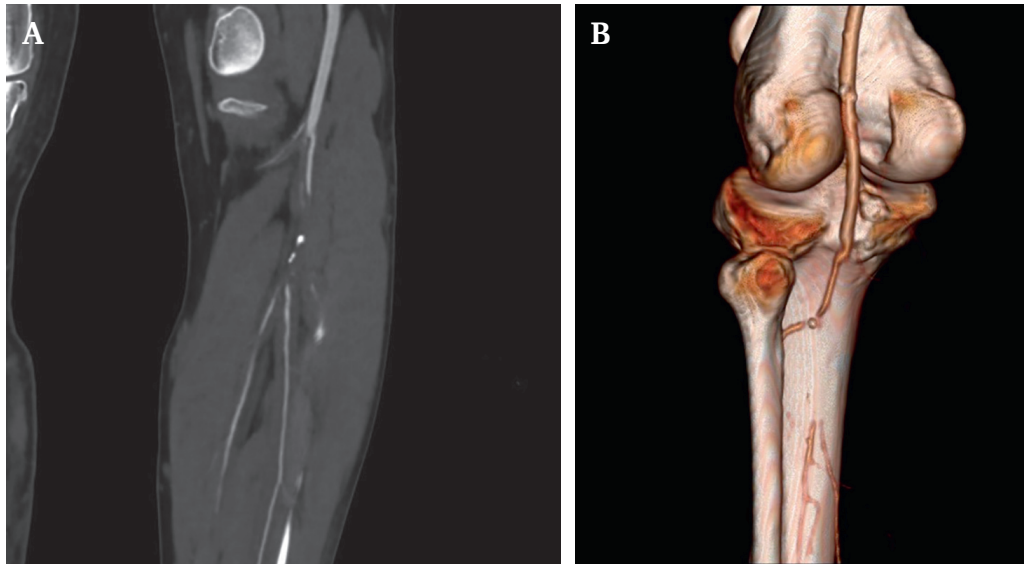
Pre-operative computed tomography angiogram images. (A) Multiplanar reconstruction showing the popliteal artery, tibioperoneal trunk, and posterior tibial artery. (B) Three dimensional reconstruction of the popliteotibial region, indicating incomplete occlusion of the distal popliteal artery and complete occlusion of the tibioperoneal trunk.
